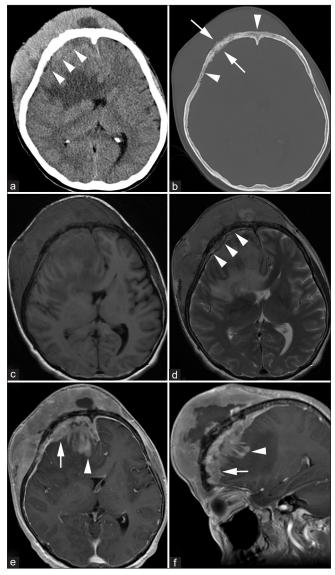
Preoperative computed tomography (CT) and magnetic resonance imaging. (a and b) Axial CT of the brain parenchyma window (a) and the bone window (b). The large extracranial component and relatively small intracranial component (arrowheads on [a]) sandwiched the cranial vault with permeative deossification (arrowheads on [b]) and periosteal reaction (arrows on [b]). (c-f) T1-weighted imaging (c), T2-weighted imaging (d), and post contrast T1-weighted imaging in the axial plane (e) and sagittal plane (f). The dura mater is raised from the cranial vault (arrowheads on [d]), and subdural extension (arrows on [e] and [f]) and brain invasion (arrowheads on [e] and [f]) are observed. Note that the cranial vault contour is preserved despite the large mass size in (b).
